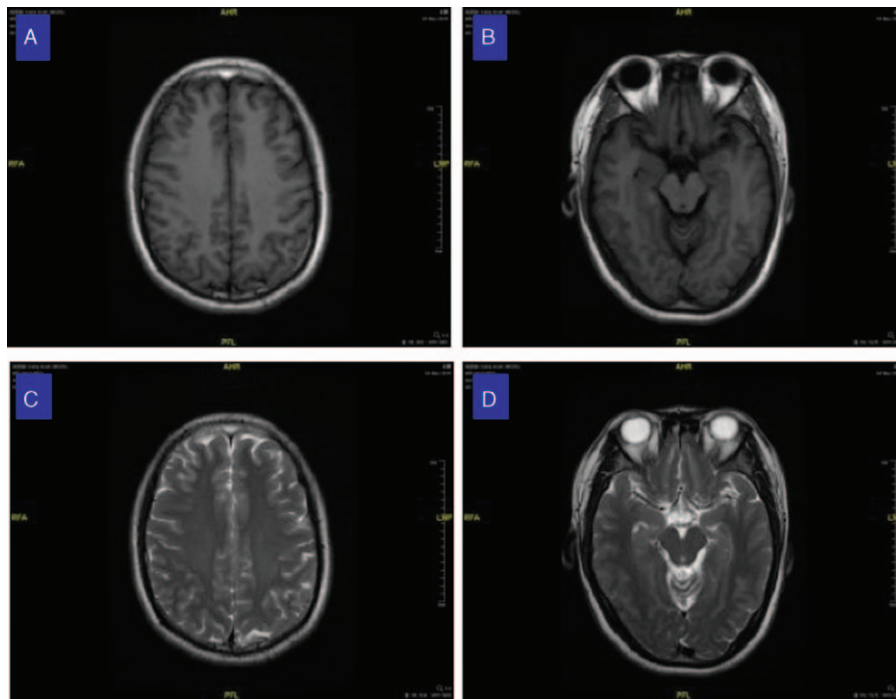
Axial T1 (A, B) and Axial T2 (C, D) weighted MR images 1 month after discharge showing that the lesions have disappeared. MR = magnetic resonance.
